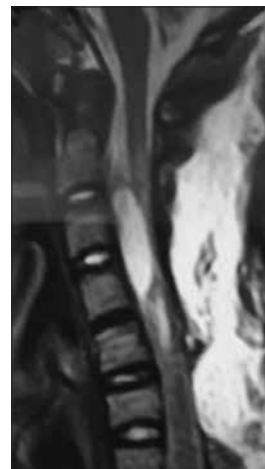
T2 magnetic resonance imaging sagittal
